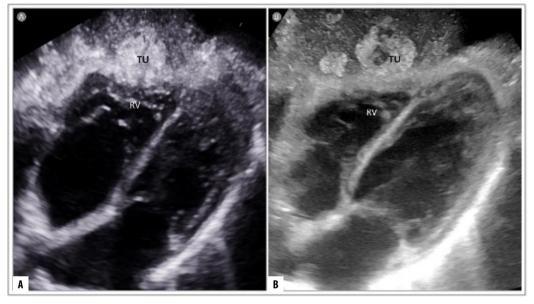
Right ventricle compression by liver metastatic tumor (Tu) - substernal echocardiographic view using cardiac sector probe (A) and convex probe (B).
